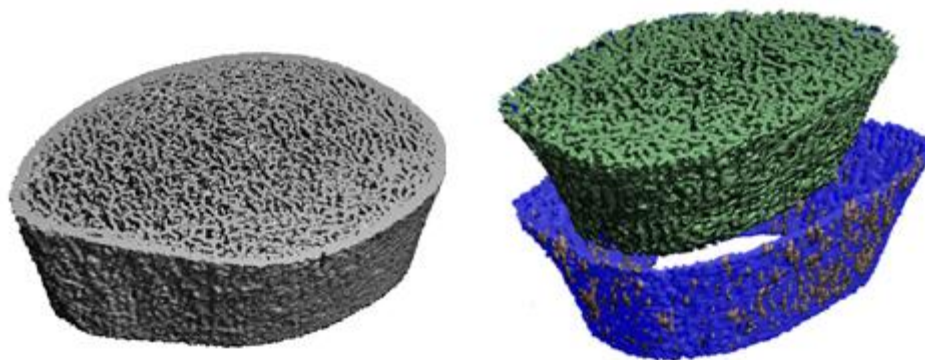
Peripheral computed tomography (pQCT) scans at distal and shaft sites of the radius and tibia.
